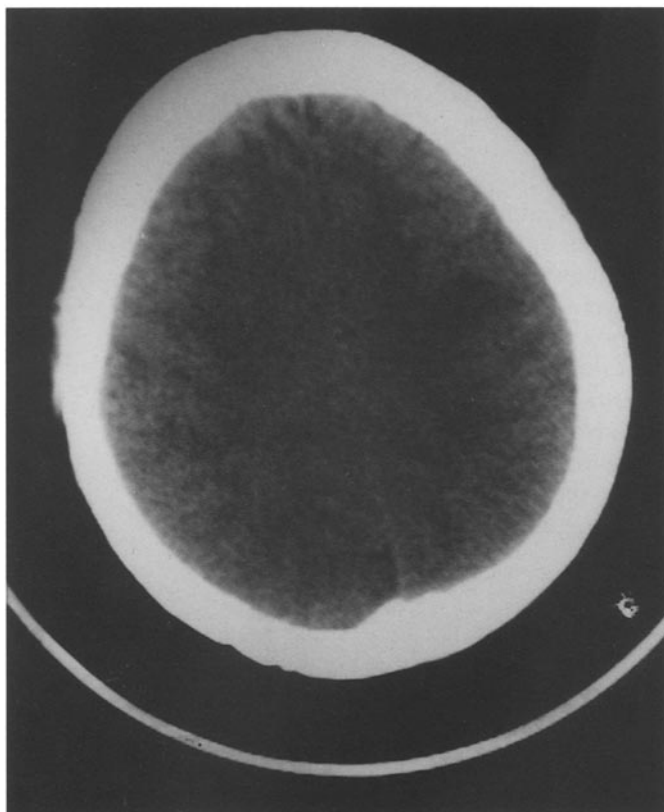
Brain CT showing white matter swelling over left frontal-parietal region.
